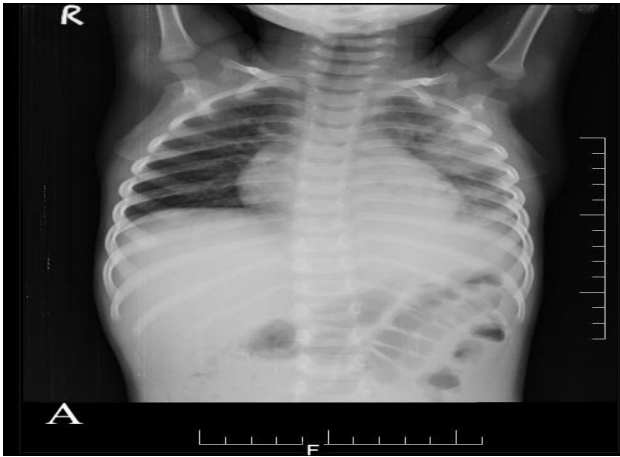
Chest radiography showing left middle and lower zone consolidation.
